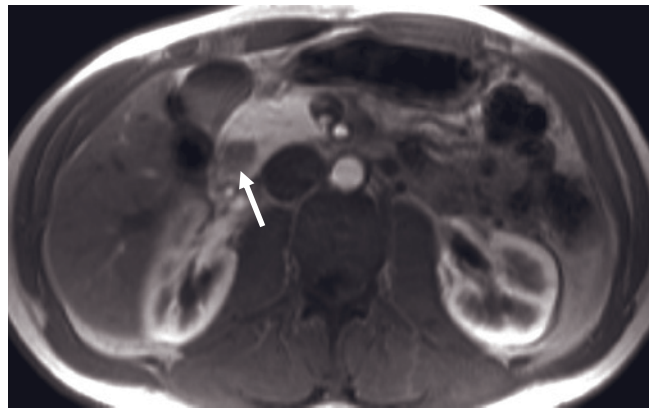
Annular pancreas. T1-weighted SGE (*a*), immediate postgadolinium T1 SGE (*b*), and 90-s postgadolinium T1 fat-suppressed SGE (*c*) images. Normal pancreatic parenchyma (arrow, *b*) surrounds the second portion of the duodenum, diagnostic for annular pancreas. This is best shown on noncontrast T1-weighted fat-suppressed and immediate postgadolinium (*b*) images.
